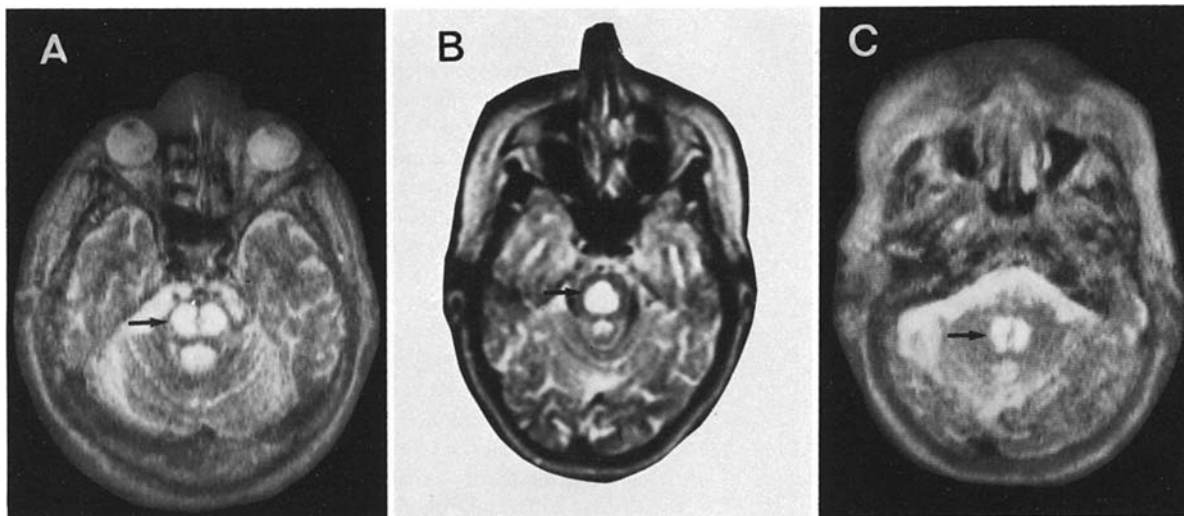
Magnetic resonance imaging in three patients with central pontine myelinolysis. MR imaging (spin-echo technique) shows an area of increased image intensity (*arrows*) occupying the basis pontis extending in B to the lower mesencephalon. In A and C the median raphe is well visualized between the two symmetrical bean-like areas in the basis pontis. (A = patient 4, repetition time 4260 ms, time echo 120 ms; B = patient 3, repetition time 3000 ms, time echo 120 ms, C = patient 1, repetition time 3000 ms, time echo 120 ms)
